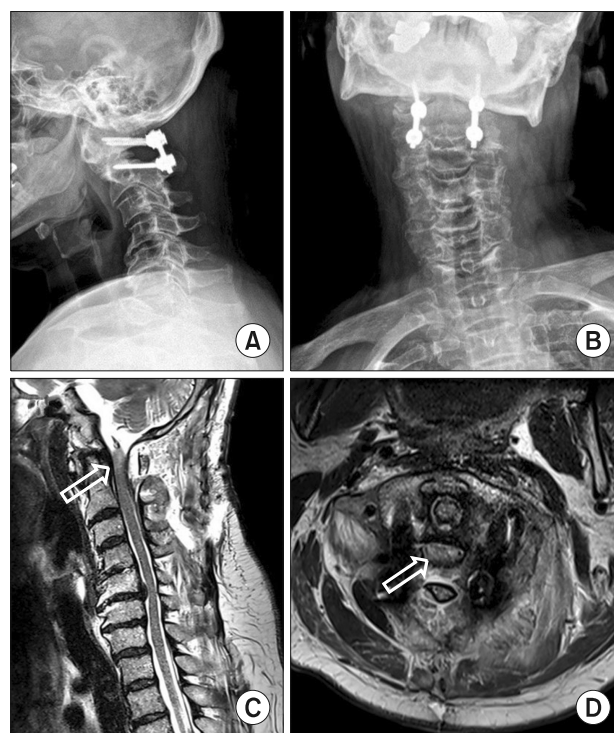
Postoperative images of the cervical spine. (A) Lateral view of cervical spine X-ray, (B) Anteroposterior view of cervical spine X-ray, (C) Sagittal view of cervical spine T2-weighted magnetic resonance image (MRI), (D) Axial view of cervical spine T2-weighted MRI. Decompressive laminectomy of C1 vertebra and posterior spinal fusion of C1-C2 operation relieved the spinal cord compression. However, compressive myelopathy is still observed (empty arrow).
